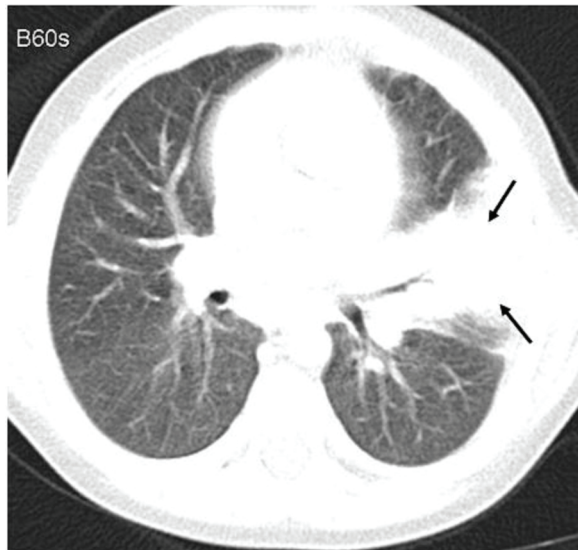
Computed tomography (CT), a lesion with a 4.5 cm diameter abscess located in the left lingular segment
